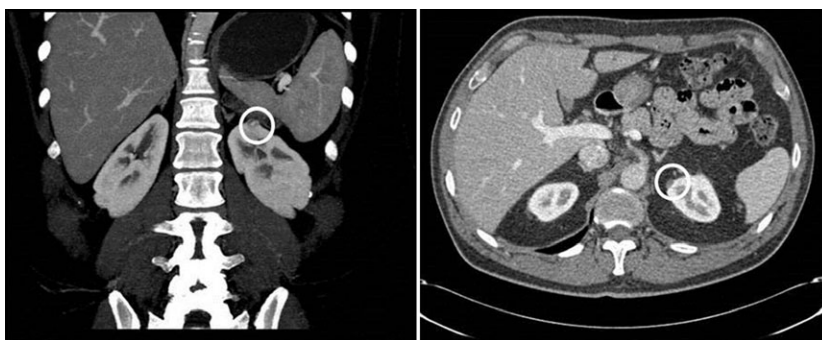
CT scan of the abdomen of a donor which demonstrated a left renal tumor in upper pole of about 0.9 cm diameter (white circle). This kidney was decided to be used for donation.
